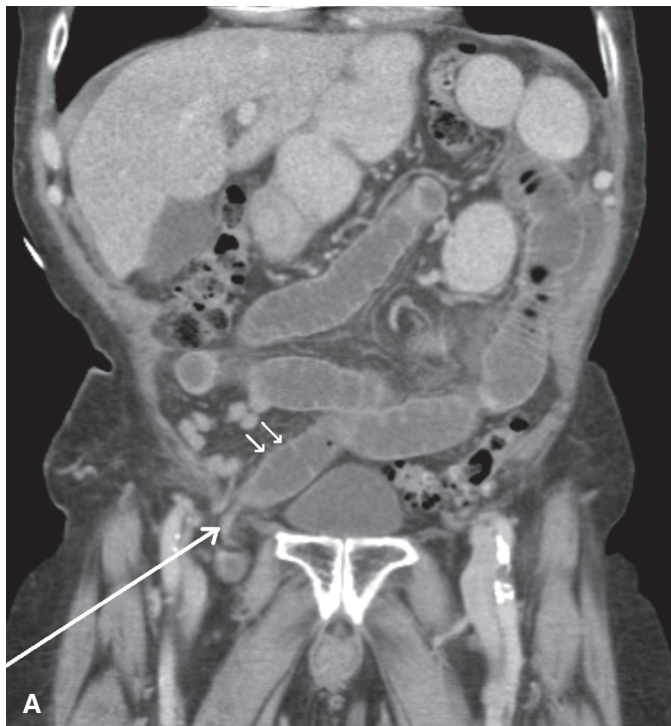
String-of-beads sign in a 77-year-old woman with a surgical history of right nephrectomy for renal cell carcinoma. The patient presented with abdominal pain. This axial, CT scan demonstrates dilated small bowel loops secondary to ventral wall hernia containing incarcerated small bowel loop (*double arrows*). The dilated intraperitoneal small bowel loops are fluid filled with small-quantity of nondependent intraluminal air giving a string-of-beads appearance (*arrow*).
